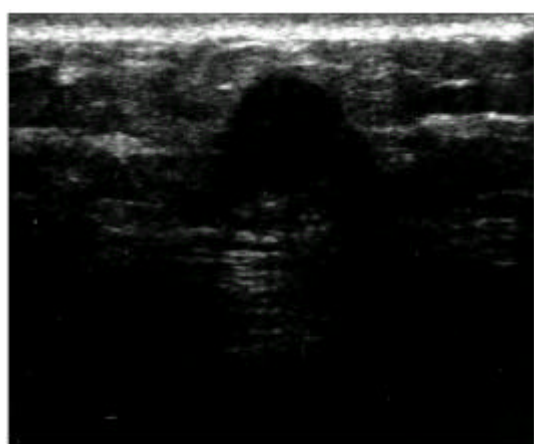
Ultrasonographic finding. It shows a relatively well-defined, hypochoic, round shaped mass density. But the mass appears kind of upright in shape.
